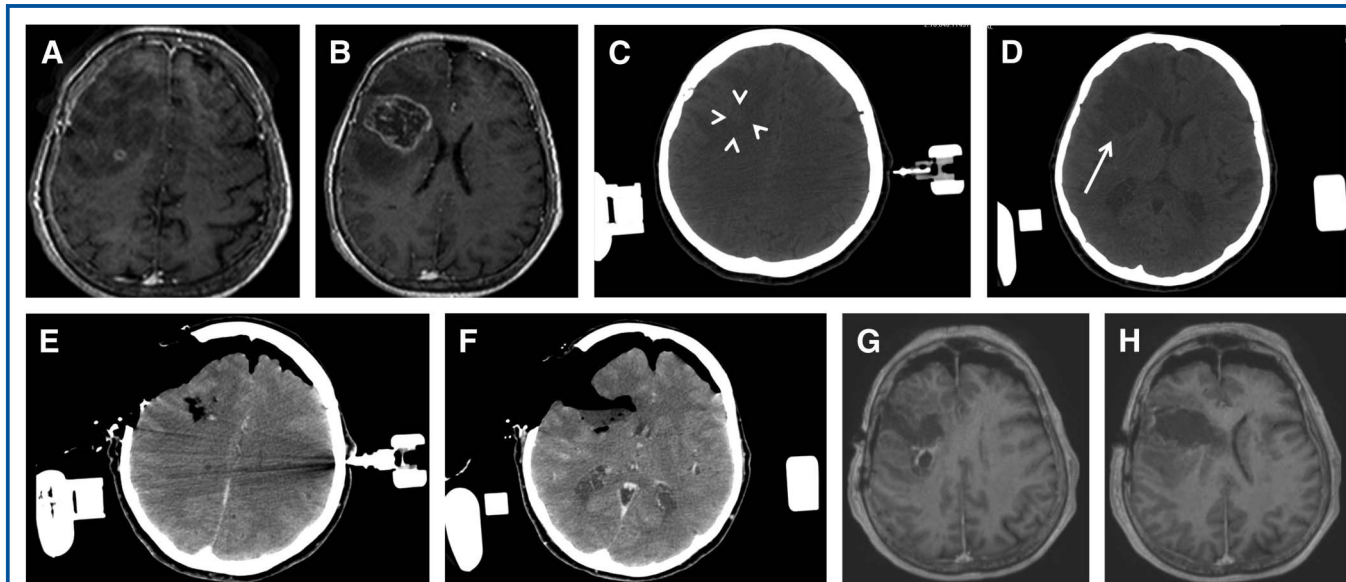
Resection of a right frontal multicentric glioblastoma assisted by intraoperative computed tomography (i-CT) is shown. Preoperative, T1-weighted, gadolinium-enhanced, magnetic resonance imaging (MRI) showing a small posterior and superior tumor nodule (A) detached from the large right frontal tumor (B). The nodule was identified on the preoperative i-CT performed after patient positioning (C, arrowheads). The large frontal mass was also depicted (D, arrow). The small nodule was first approached and resected. A new postcontrast i-CT scan confirmed the resection and was used to update the data for navigation (E). The resection of the frontal mass was finally confirmed by the last postcontrast i-CT scan (F). Postoperative T1-weighted, gadolinium-enhanced, MRI demonstrated the complete resection of the multicentric neoplasm (G, H).
